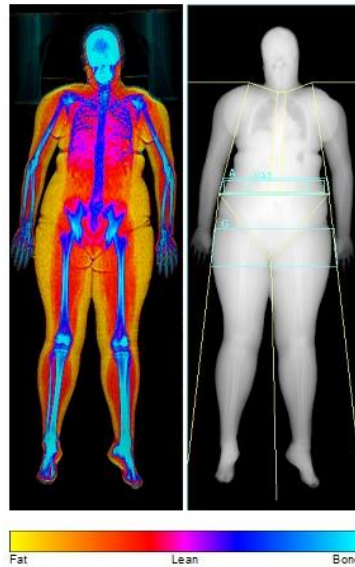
Body composition analysis by Dual energy X-ray Absorptiometry (DXA)
